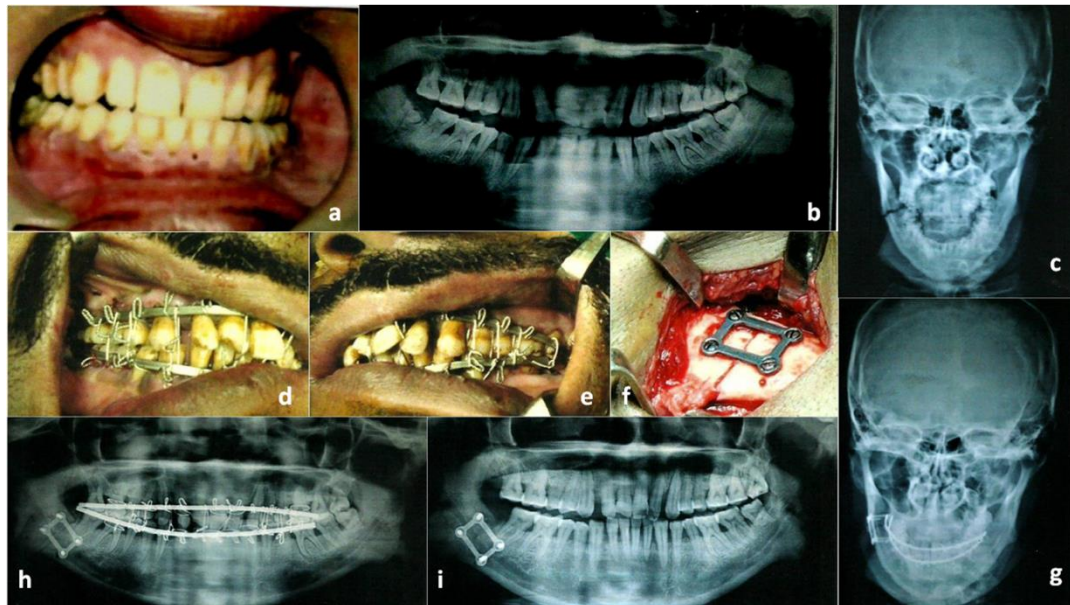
(a) Preoperative occlusion, (b) Preoperative orthopantomogram, (c) Preoperative PA skull, (d) Intermaxillary fixation and postoperative occlusion on right side, (e) Intermaxillary fixation and postoperative occlusion on left side, (f) Fixation of fracture site with titanium 3D plate, (g) 1 week postoperative PA skull, (h) 1 week postoperative orthopantomogram, (i) 4 months postoperative orthopantomogram.
